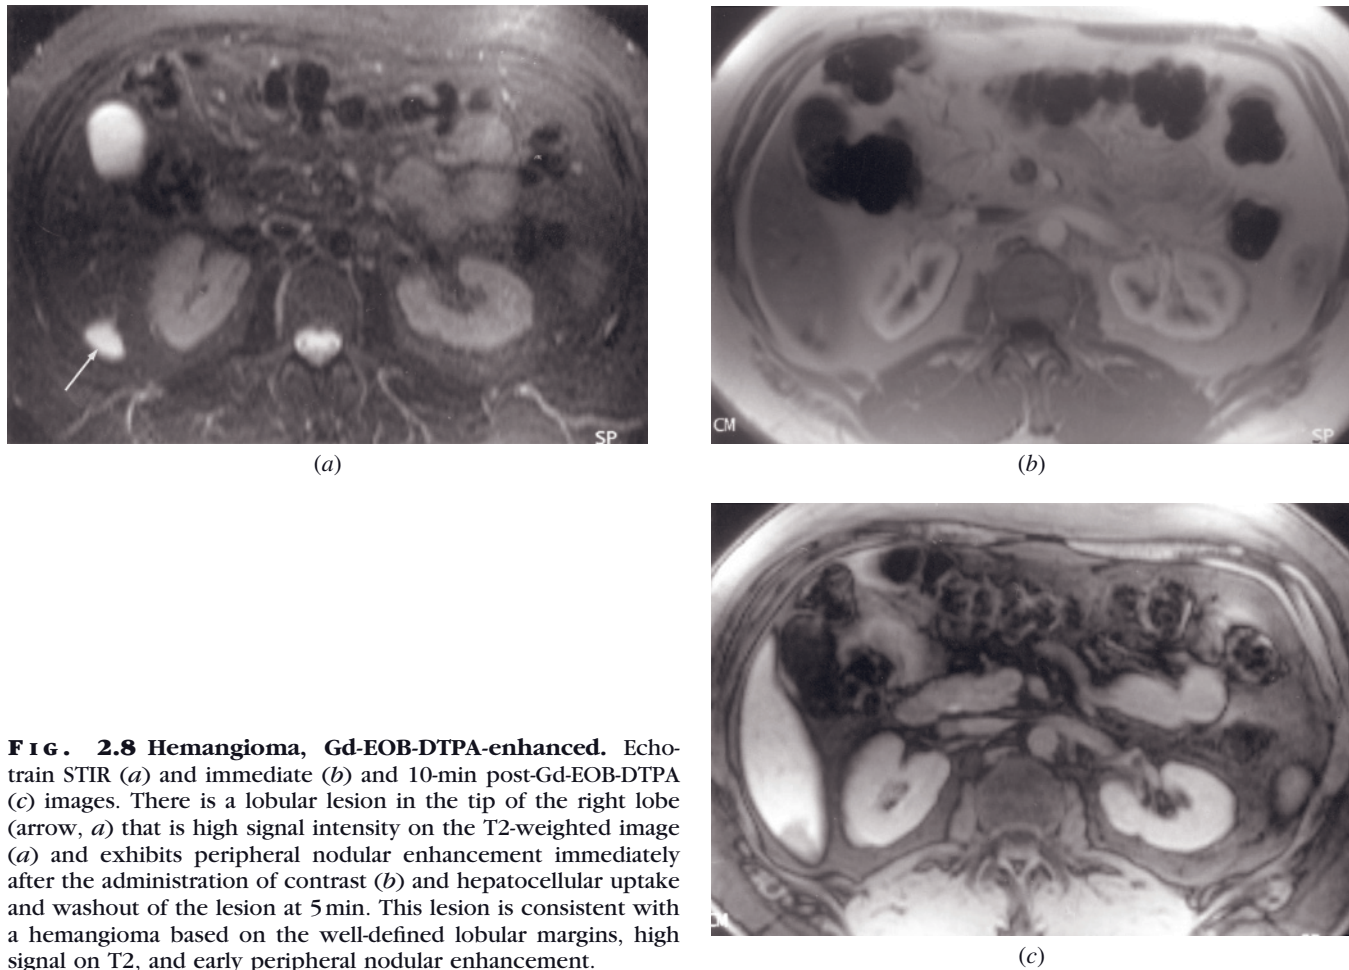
Hemangioma, Gd-EOB-DTPA-enhanced. Echo-train STIR (*a*) and immediate (*b*) and 10-min post-Gd-EOB-DTPA (*c*) images. There is a lobular lesion in the tip of the right lobe (arrow, *a*) that is high signal intensity on the T2-weighted image (*a*) and exhibits peripheral nodular enhancement immediately after the administration of contrast (*b*) and hepatocellular uptake and washout of the lesion at 5 min. This lesion is consistent with a hemangioma based on the well-defined lobular margins, high signal on T2, and early peripheral nodular enhancement.
